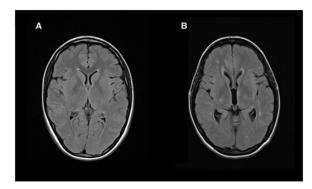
Axial MRI brain results of patients with recent diagnosis of MS. (A) display normal thalamic volume and third ventricular width (patient has relapsing—remitting MS). (B) display thalamic atrophy with an elevation in a width of 3rd ventricular (patient with primary-progressive MS) [²⁴].
